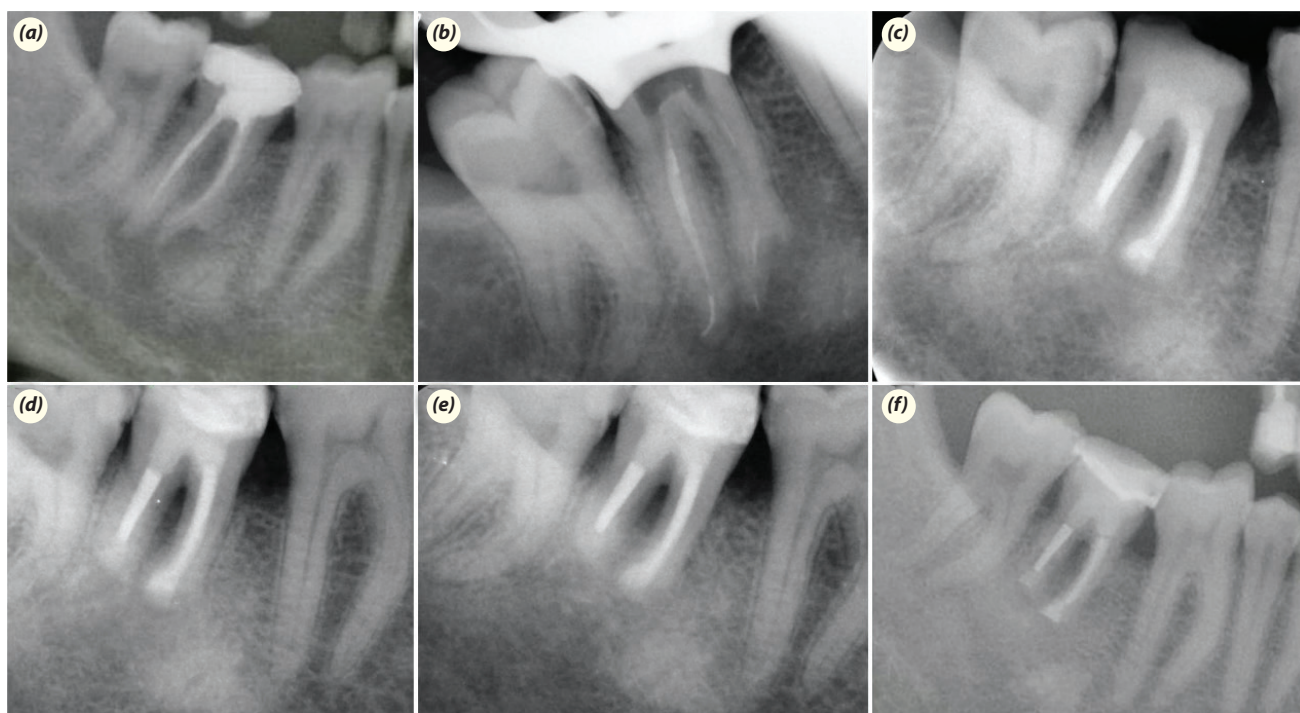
Radiographic images. (a) Preoperative, (b) A fractured file in the distal root during retreatment, (c) Immediate postoperative radiograph after IR, (d) 3-month follow-up, (e) 6-month follow-up, (f) 12-month follow-up.
